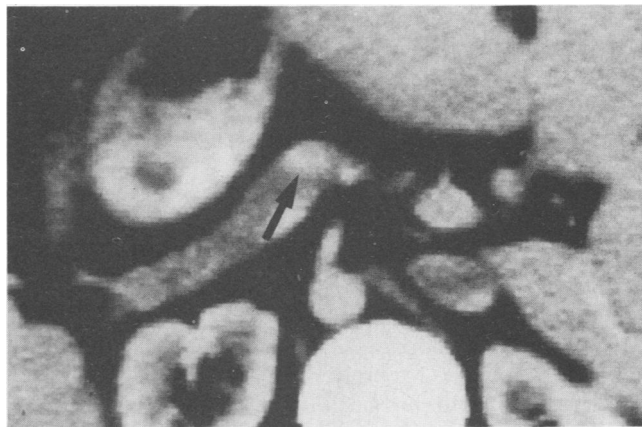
Computed tomography scan of the pancreas showing an enhancing tumor (black arrow). (From Stephens DH: *Pancreas: Neoplastic lesions*, In Margulis AR, Burhenne HJ (Eds): *Alimentary Tract Radiology*, Vol 4. St. Louis, CV Mosby, 1989.)
